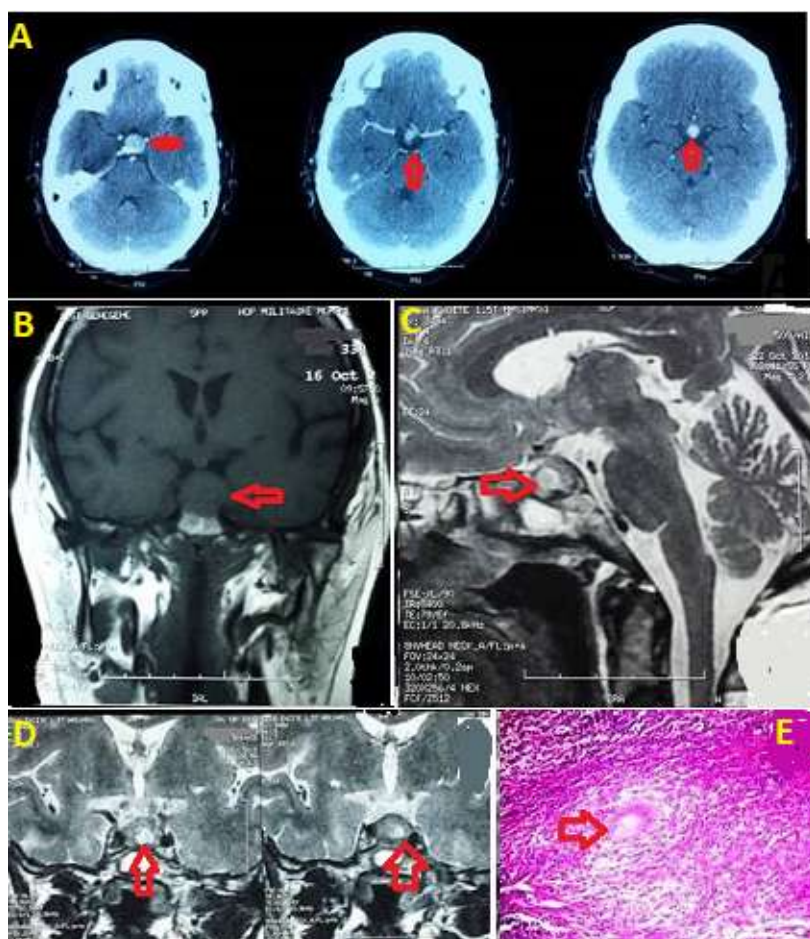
pituitary CT scan in injected axial section showing a sellar lesion taking the contrast (A), pituitary MRI in frontal section sequence T1 (B), sagittal section sequence T2 (C), frontal section sequence T2 (D) showing a pituitary abscess. anatomo-pathological study showing gigantocellular epithelioma (E)
